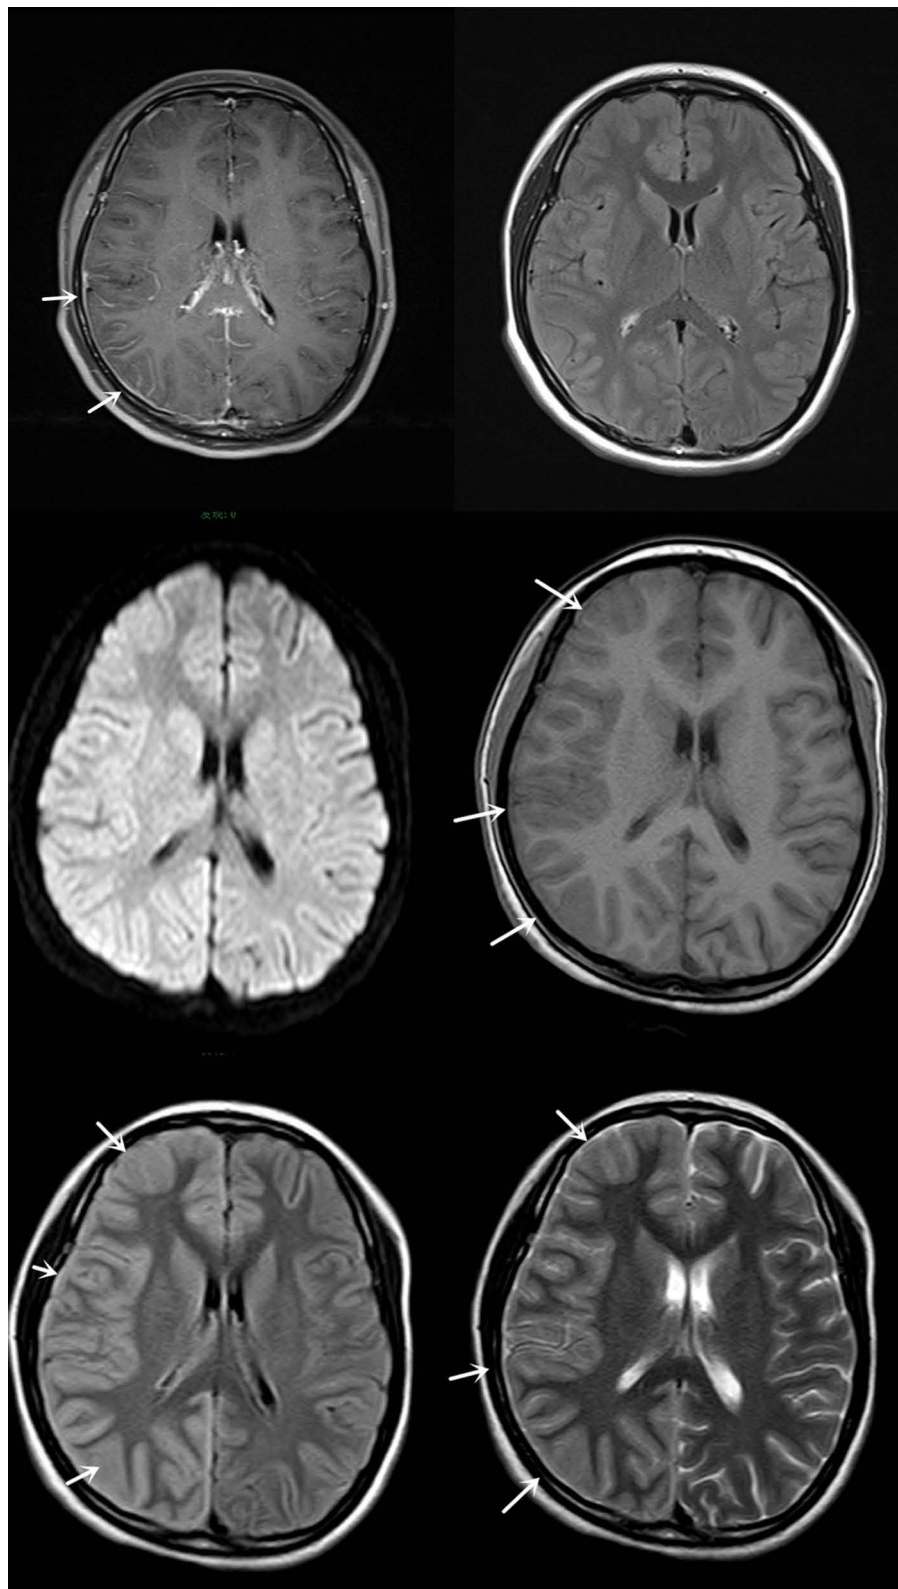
Cranial MRI at the time of admission and reviewed after the symptoms worsened. (The arrow indicates the swollen area).
